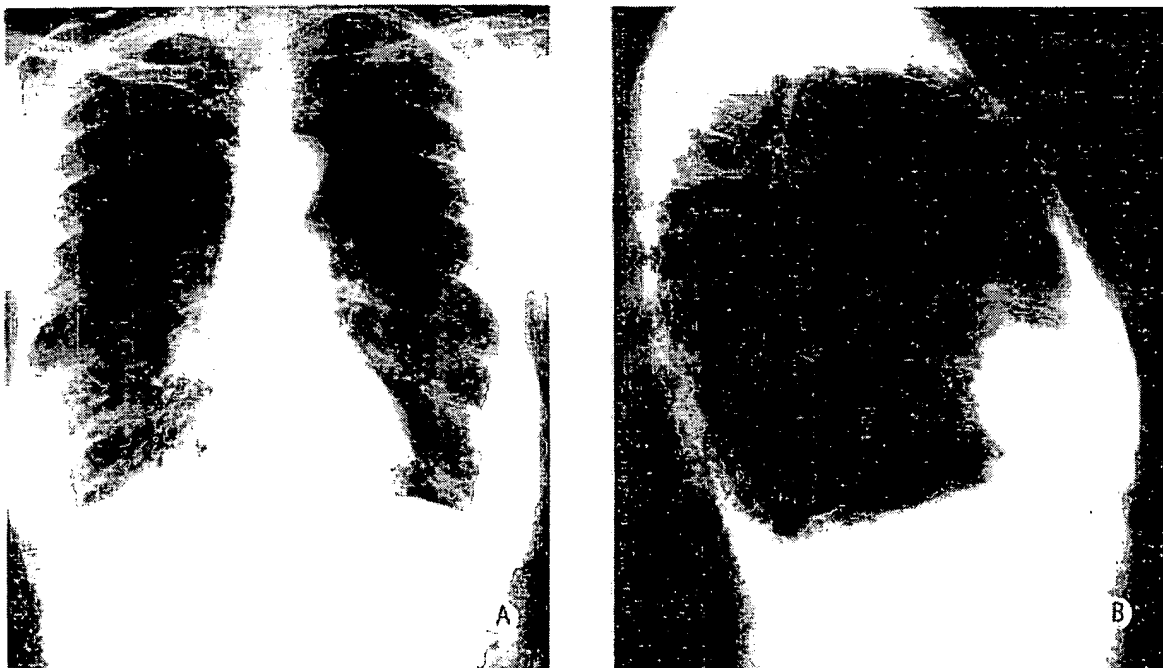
Case 2. (A and B) Preoperative posteroanterior and lateral chest roentgenograms showing overdistended lungs. Upper two thirds of both lungs occupied by large bullae.
